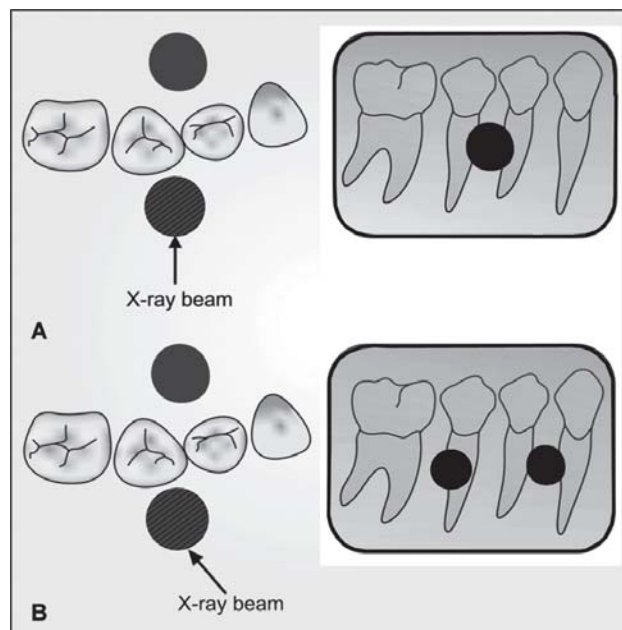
Buccal and lingual objects shift positions when the direction of the X-ray beam is changed. A. Buccal (cross hatched circle) and lingual (black circle) are superimposed in the original radiograph. B. If the tube head is shifted in the mesial direction, the buccal object moves distally and the lingual object moves mesially (Same Direction = Lingual; Opposite Direction = Buccal)
